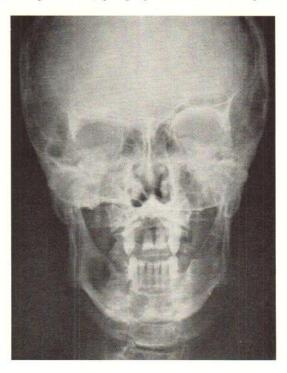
Case 1. Roentgenogram showing several large bilateral jaw cysts, those most evident being situated in the molar-ramus area.
